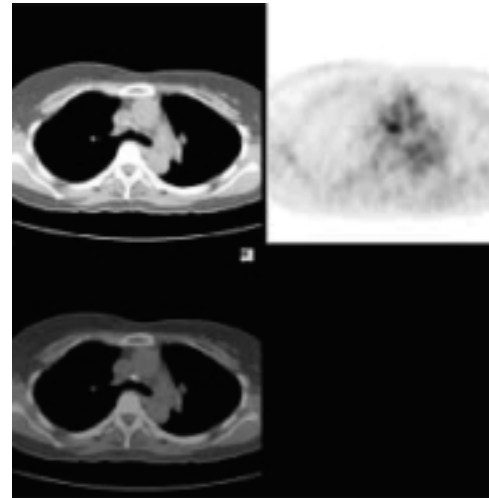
A 7-mm precarinal lesion in PET/CT.
